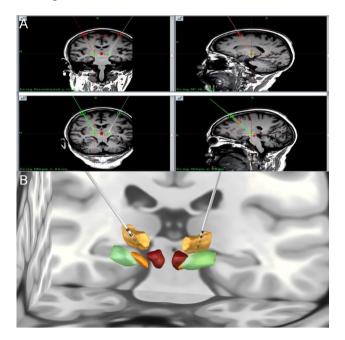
(A) Preoperative Fusion and Needle Path Visualization in Surgi-Plan; The image in the lower left corner indicates that the patient has a mild degree of cerebellar atrophy, but it does not affect the implantation of the electrodes. (B) Fusion of patient's postoperative CT with MRI using Lead DBS software, enabling three-dimensional reconstruction of electrode positions; yellow cluster represents the ventral intermediate nucleus (VIM) of the thalamus
